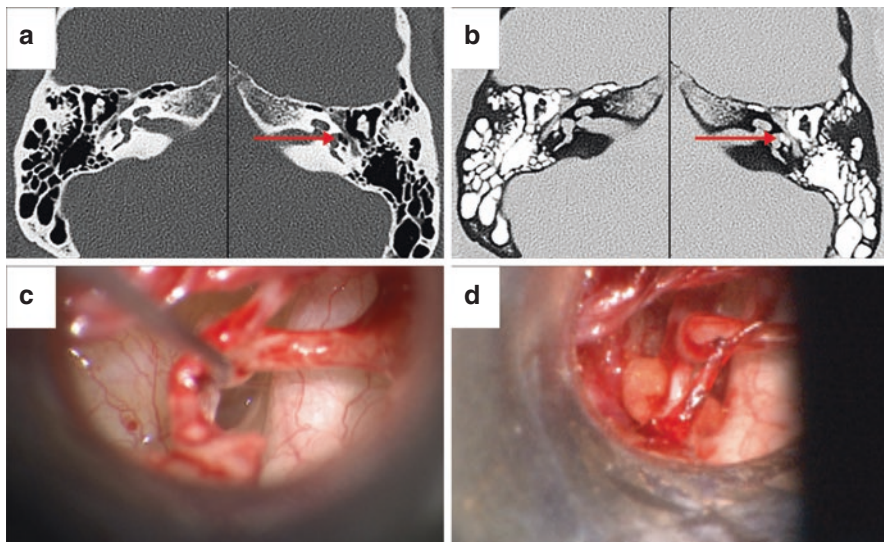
Membranous left stapes footplate (arrows) (a) normal axial CT scan. (b) Invert function shows membranous stapes footplate clearly. (c) Intraoperative view in the same patient. (d) Fat grafting. (Reproduced with permission of *Annals of Otology, Rhinology & Laryngology* [8])
